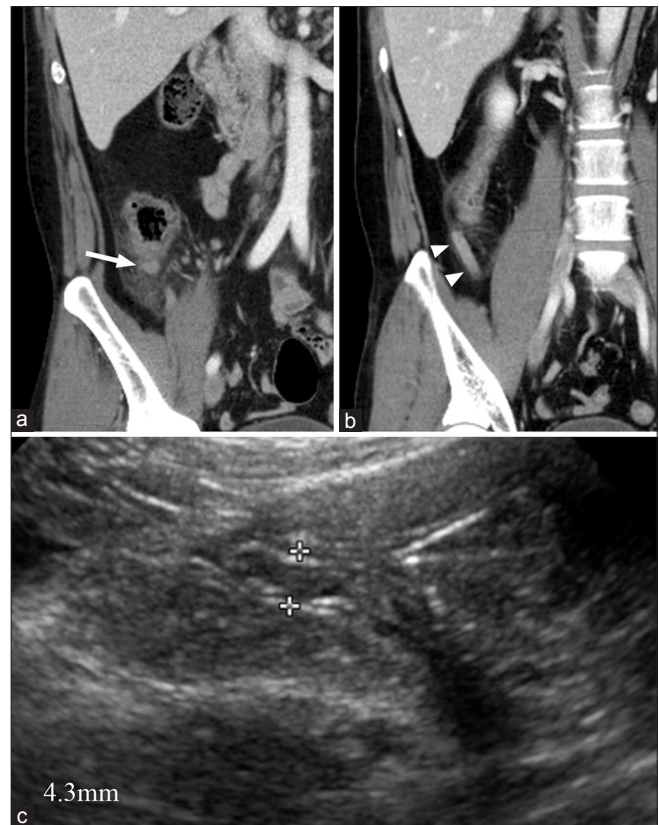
A 44-year-old male diagnosed as acute diverticulitis with negative appendicitis on both reviewers' computed tomography reassessment and ultrasound report. Contrast-enhanced coronal reformat computed tomography images (a and b) show cecal diverticulitis (arrow) and periappendicitis (arrowhead). On grayscale US (c), appendiceal diameter is within the normal range (4.3 mm). The patient underwent appendectomy by surgeon's decision. The pathological report was serosal congestion (negative appendicitis) period
